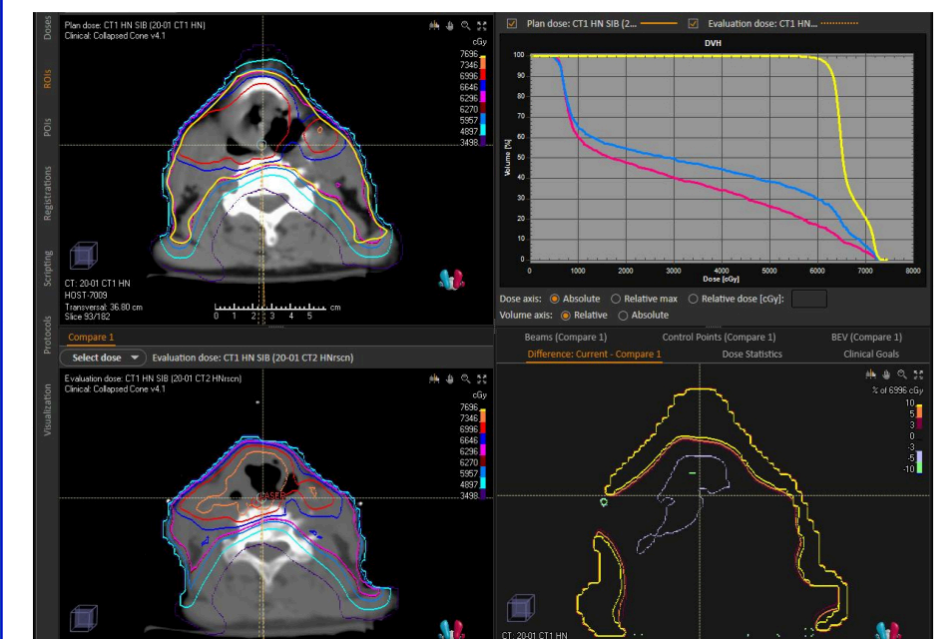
One of patients detected by the monitoring system Right upper: Planned CT. Right lower: CBCT) in the early stage of the treatments. OAP is obviously needed.
